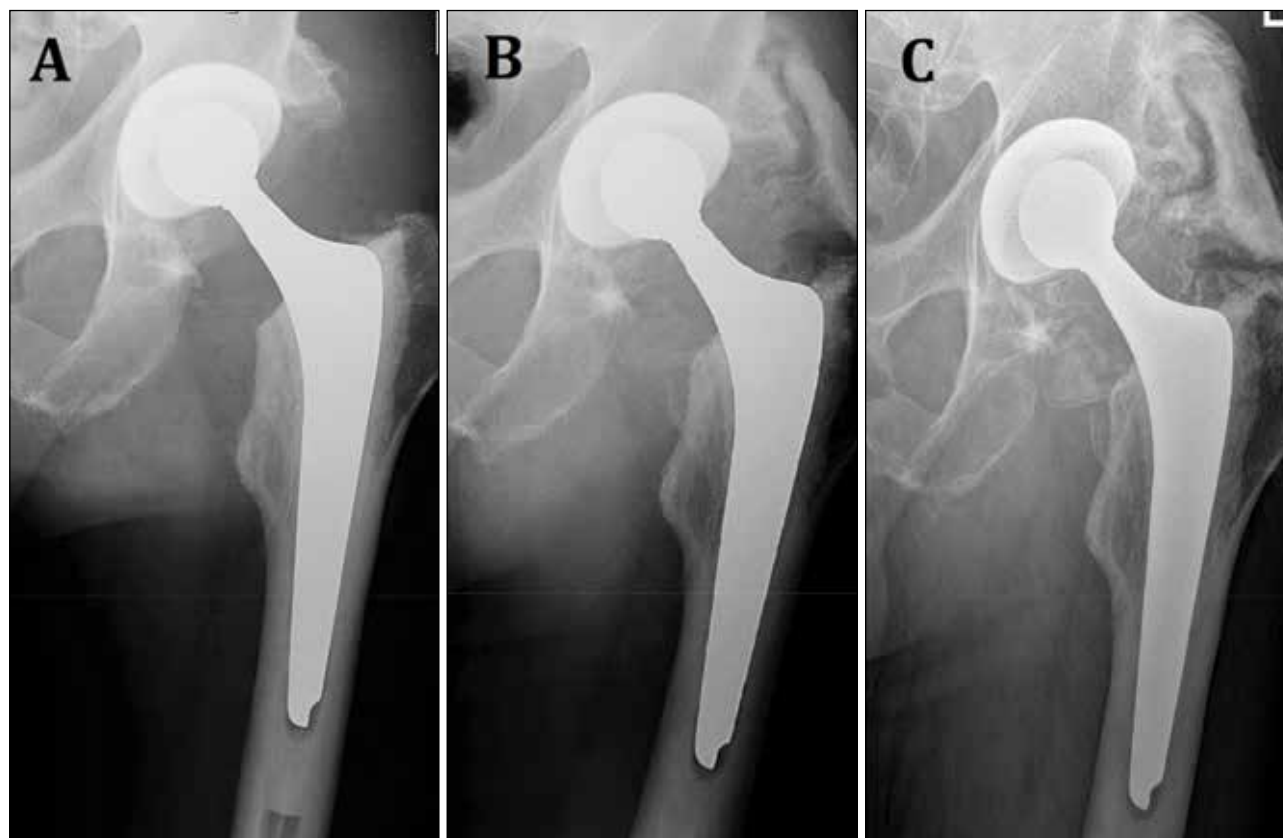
Heterotopic ossification formation after elective primary hip arthroplasty A. Post-operative x-ray scan B. Radiographic imaging at the 1-year follow-up C. Heterotopic ossification presence 2 years after the procedure (Source: own material).*
